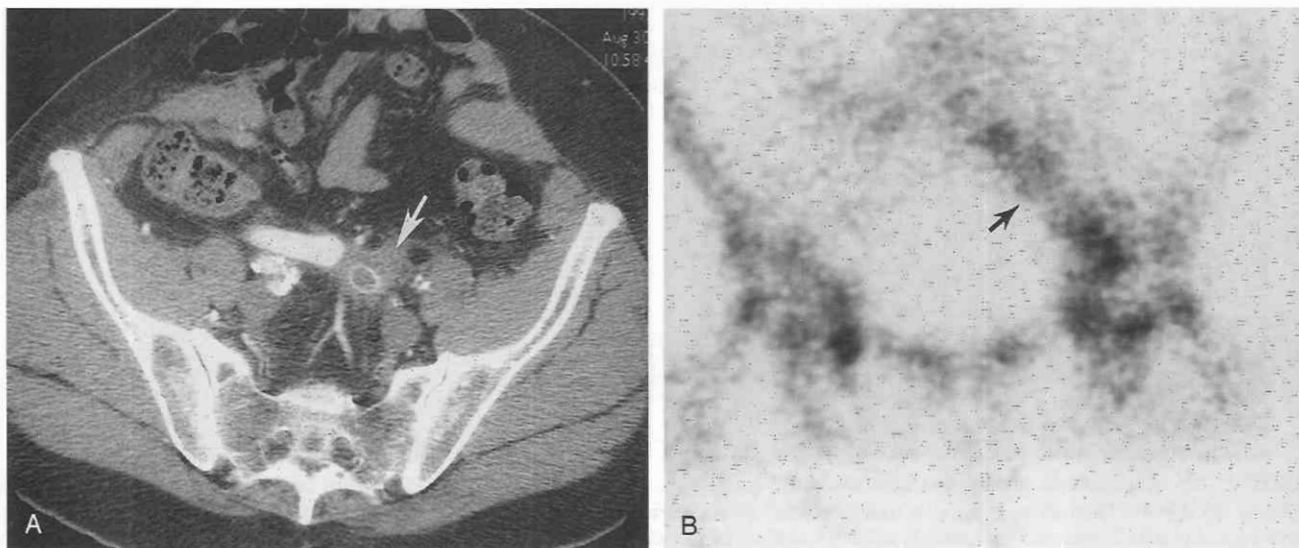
Infected aortic graft. *A*, Unenhanced CT scan shows fluid-attenuation material (arrow) surrounding the left iliac limb of an aortobifemoral Y graft. In this case, the infection is not caused by a gas-producing organism. *B*, Anterior view from an indium-labeled leukocyte scan demonstrates increased uptake in the left external iliac region (arrow) corresponding to the infected aortobifemoral graft.
